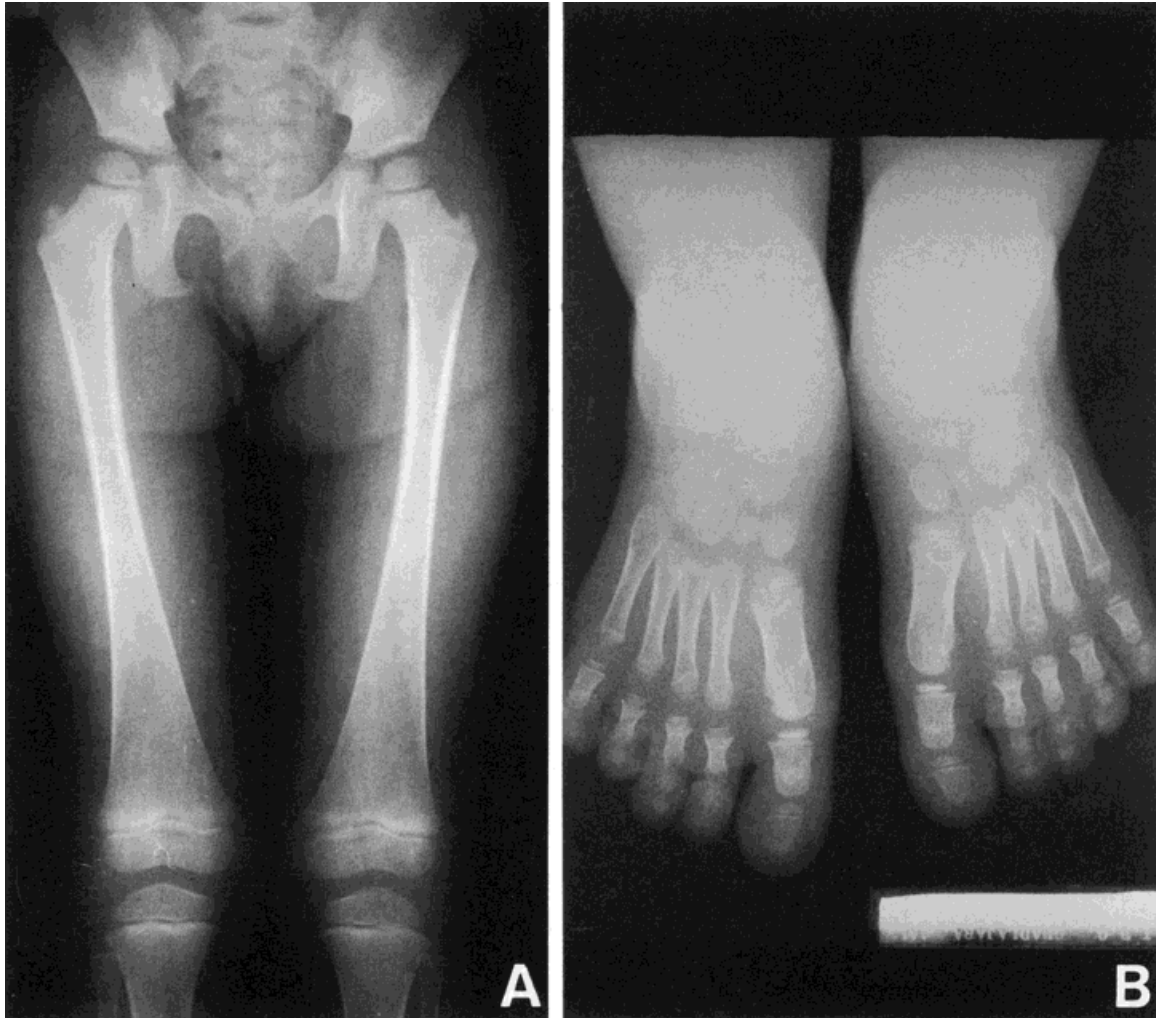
Patient D, X-rays. A: Bilateral coxa-valga, long bones with an "Erlenmeyer-flask" appearance. B: Broadened first metatarsal and short distal phalanx of the first toes.
